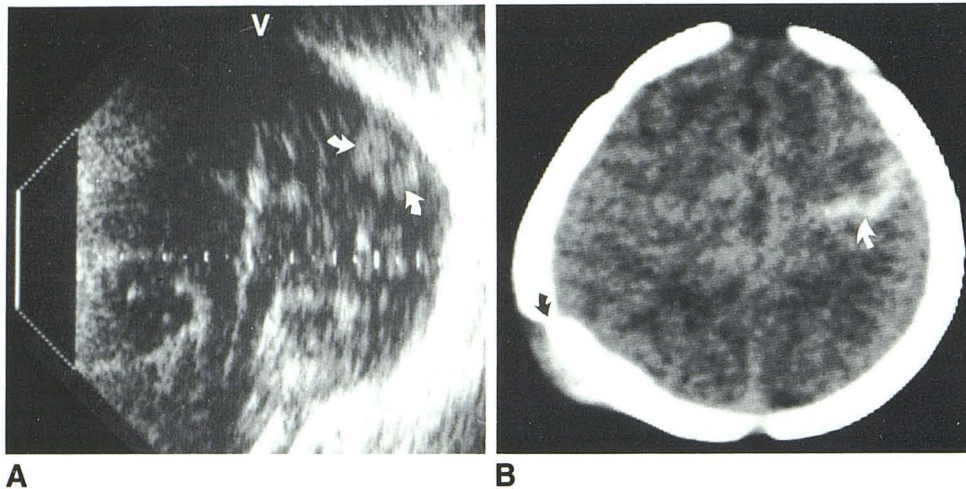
A, Coronal sonogram obtained through right lateral skull shows hyperechoic contusion in left parietal cortex (arrows). V = vertex of head. B, CT scan shows hemorrhagic contusion in a left parietal gyrus (white arrow) opposite right parietal fracture (black arrow).
